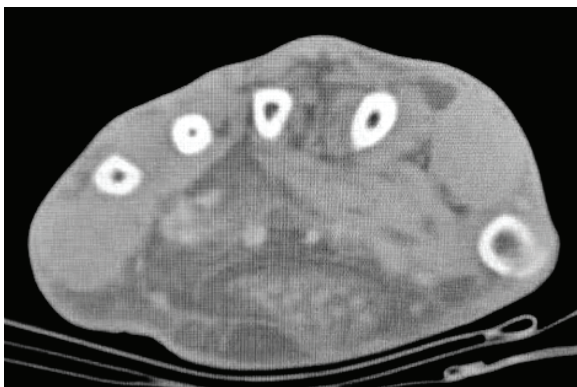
Preoperative CT axial image of the right hand showing a solid mass in the soft tissue area of the right palm with hypodensity.
